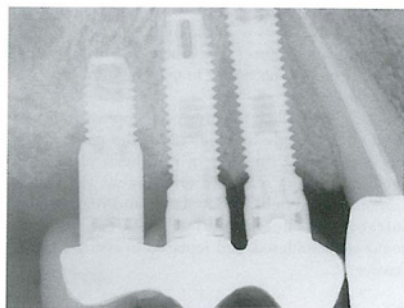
Radiograph of refaced fractured implant with refabricated ceramometal fixed prosthesis. Note the shortened cantilever.
